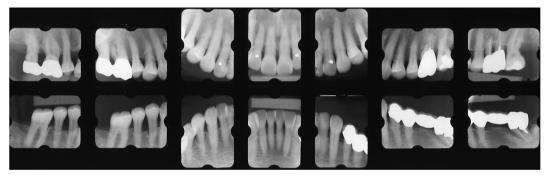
Radiographic view after 12 years of SPT
